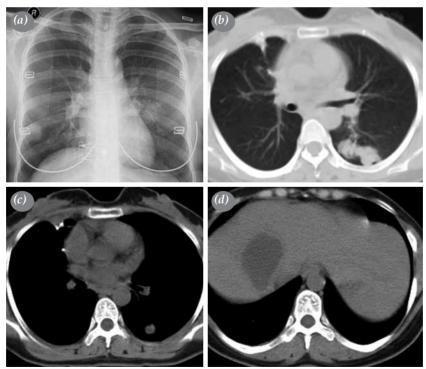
A thoracic computed tomography and conventional radiography of a 28-year-old female showing multiple nodules. (a) Chest radiography showing multiple alveolar echinococcosis lesions in the right lower and left middle zone. (b-d) Computed tomography scans showing lesions in the right middle lobe and superior segment of the left lower lobe with an alveolar echinococcosis lesion of the liver (*Case 2*).
